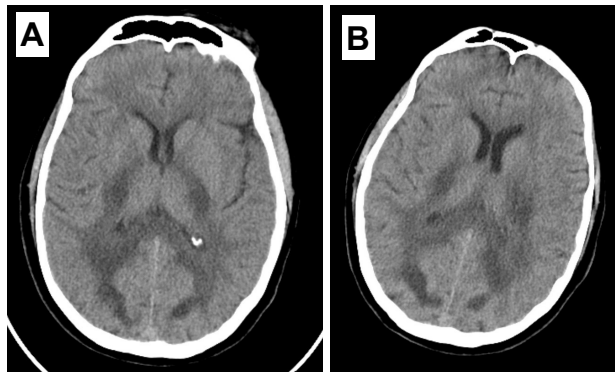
A & B: Computed tomography (CT) scan of head without contrast (axial view) showing extensive bilateral white matter hypodensities.
